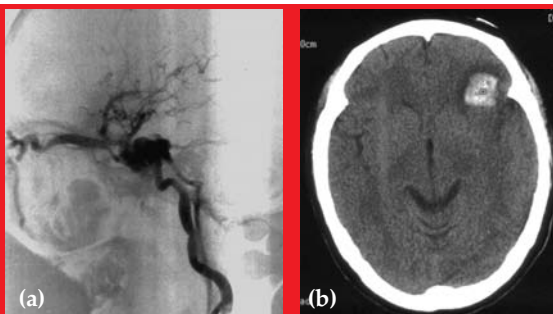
(a) Angiogram, lateral view, showing a direct CCF. (b) CT scan, axial view, showing intracerebral haemorrhage
